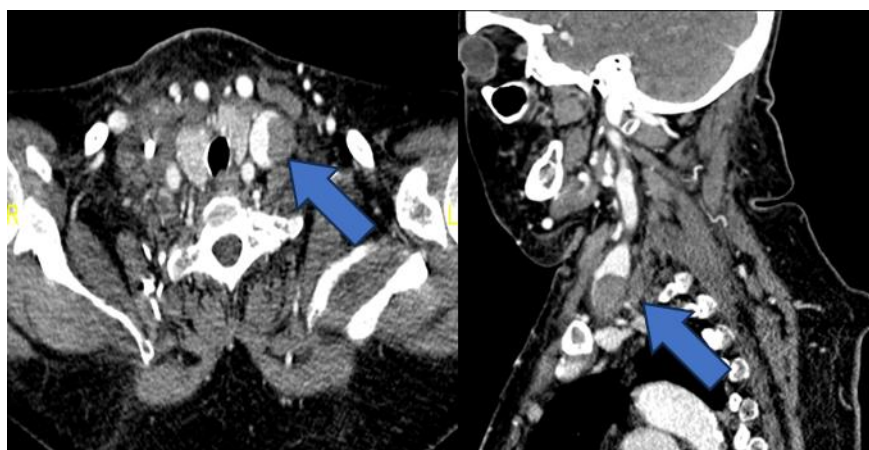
Contrast enhanced CT neck in axial and sagittal view showed eccentric filling defect in the left internal jugular vein in keeping with thrombosis (Arrow).
